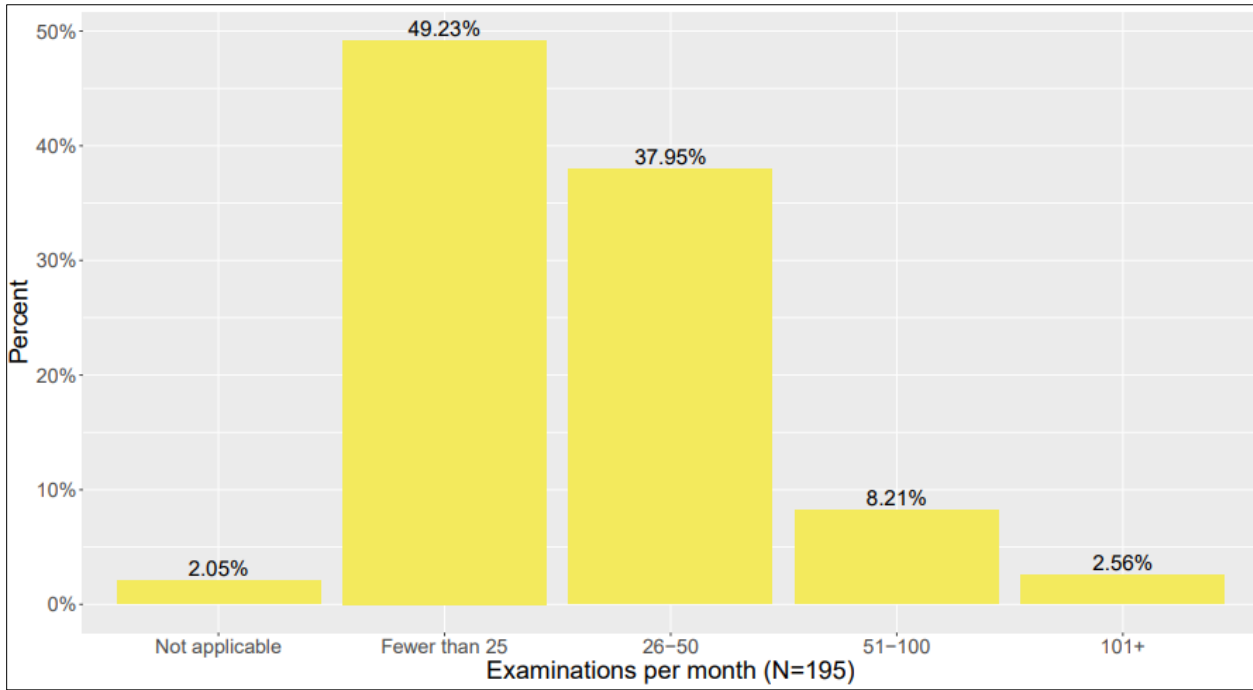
FE ultrasound exams performed per month in 2016 survey responses
